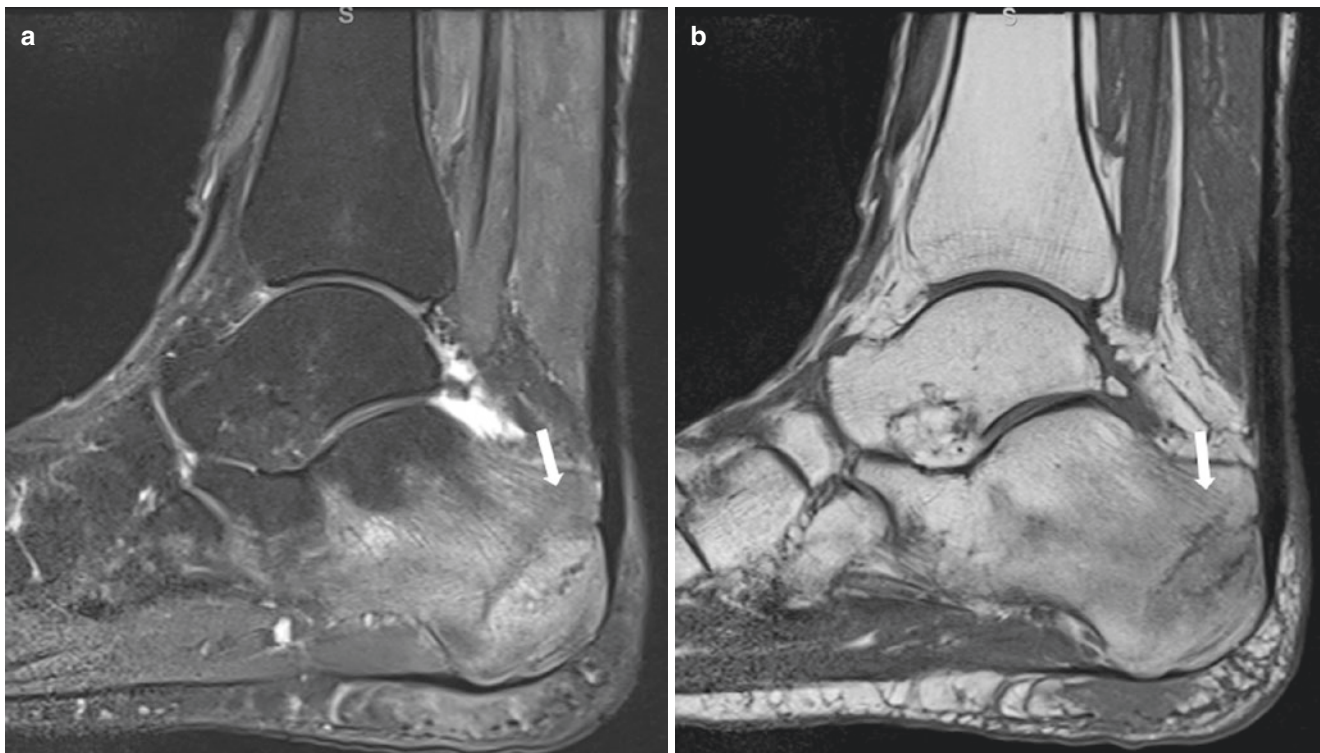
Calcaneal stress fracture. Sagittal fat-suppressed T2- (a) and proton density weighted (b) MR images of the left ankle demonstrate incomplete stress fractures with surrounding bone marrow edema within the posterior third of the calcaneus (arrows)
